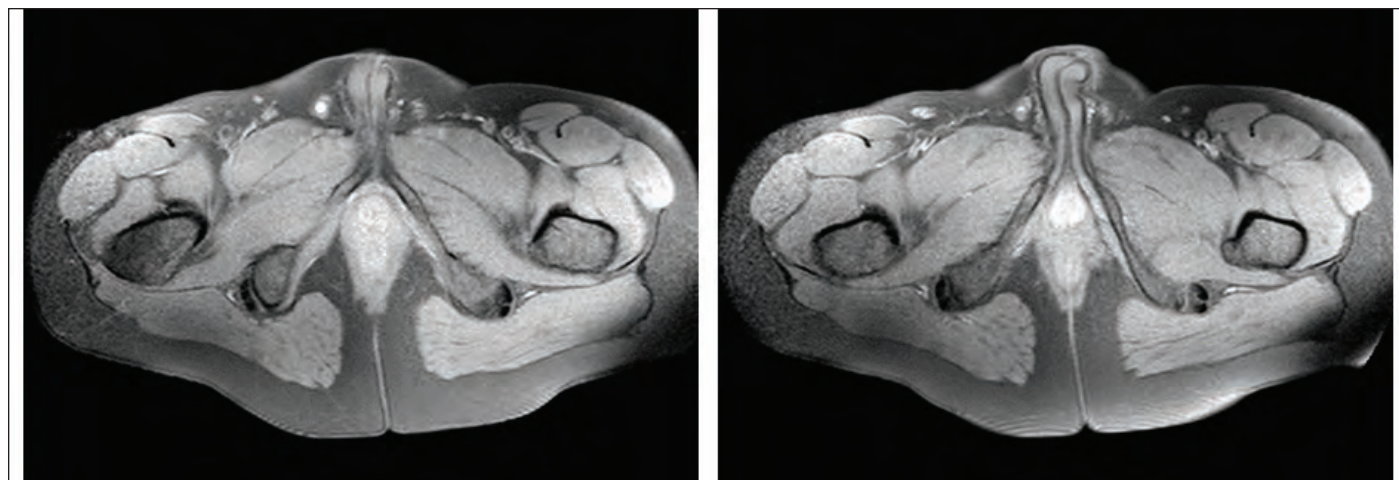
Fat-compressed axial T1A magnetic resonance images demonstrated thrombosed tubular venous structure with increased wall thickness and focal diameter increase within the right spermatic cord. Within this venous structure, intraluminal signal intensity was increased.
